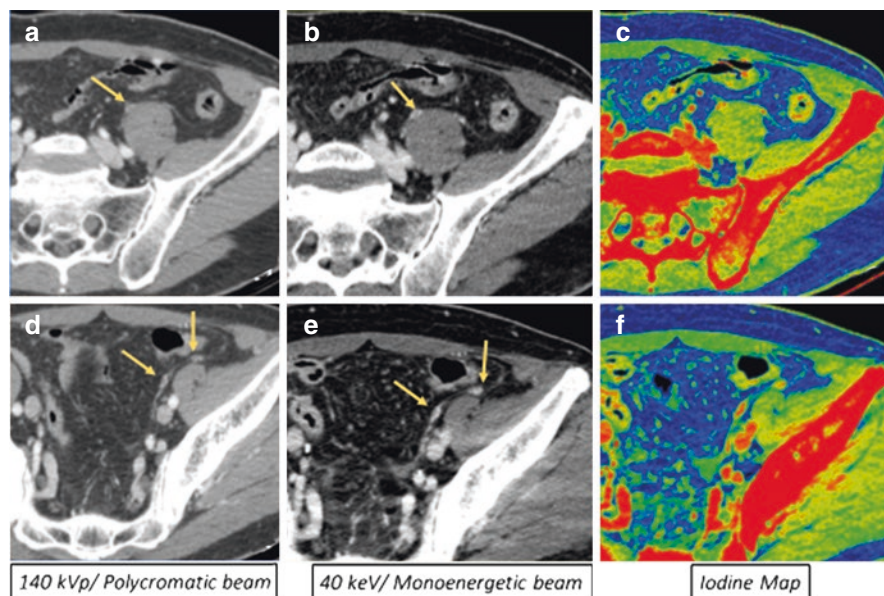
Small nodules of peritoneal carcinomatosis in a 67-year-old man with a diffuse Laurén type gastric cancer. If compared to standard computed tomography acquisition at 140 kVp (a, d), images at 40 keV (b, e) and iodine maps (c, f) derived from the dual-energy protocol improve contrast resolution and visualization of the lesions
